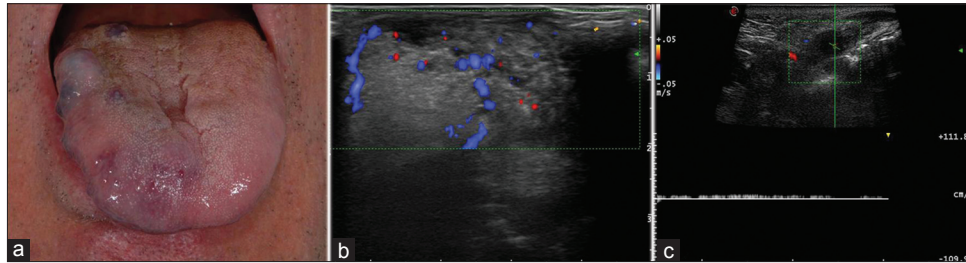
(a) Clinical image arteriovenous malformations of the tongue. (b) Color-Doppler US image (longitudinal plane), with a hypoechoic lesion presented diffuse vascular signals within the lesion. (c) Arterial feeding vessels were easily depicted
